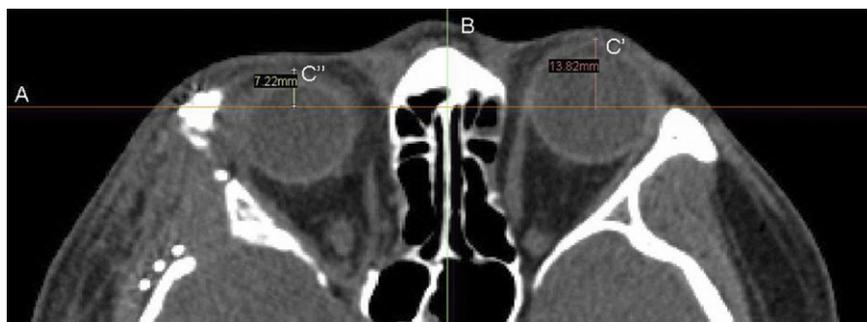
Computed tomography (CT) showing the enophthalmos of the right orbit. CT data were imported into the software package Mimics 8.11. On an axial CT scan, a line (A) perpendicular to the nasal septum (B) was drawn from the most prominent point of the zygomatic bone of healthy side extending through the fractured orbit. From this line, perpendicular lines to the most prominent point of the cornea on each side were laid (C' healthy side; C'' fractured side). The difference between the length of C' and C'' represents the amount of exophthalmos.
